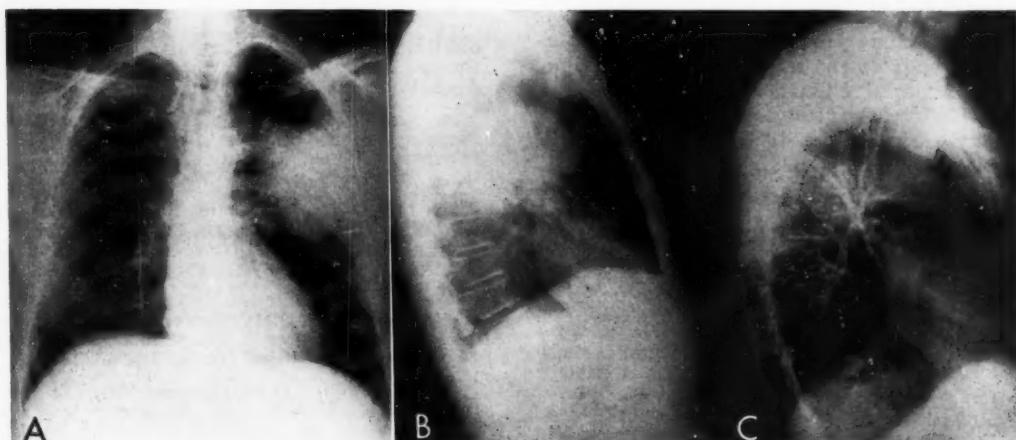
a) Postero-anterior and b) lateral roentgenograms of the chest show a sharply circumscribed somewhat rounded consolidation of the axillary portion of the left upper lobe, of proven pneumococcal etiology. The round shape suggests centrifugal spread.
